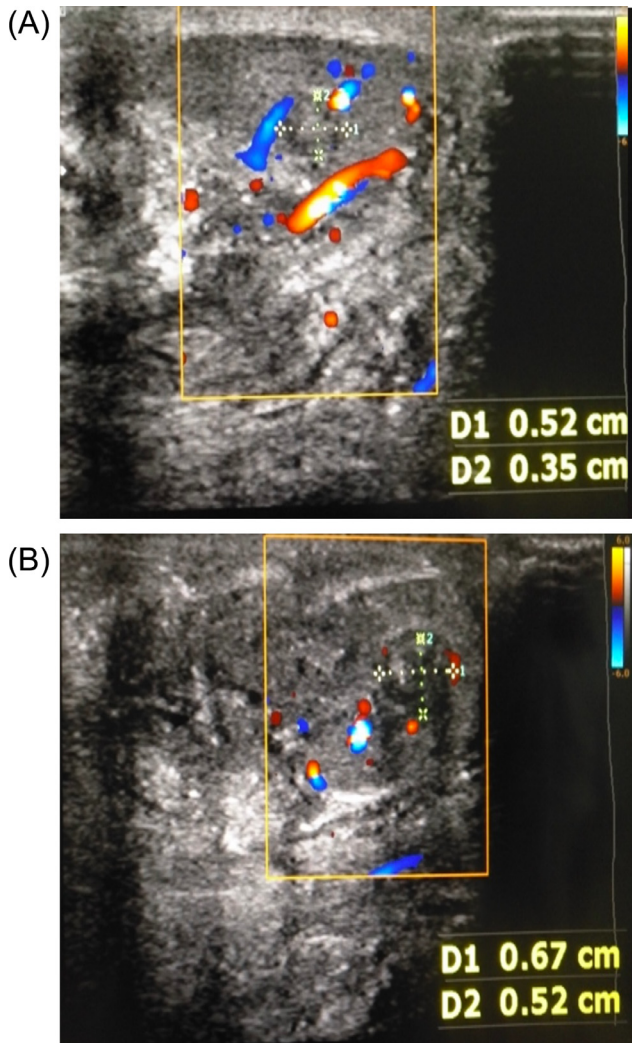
(A) Color Doppler US of scrotum showing iso to heteroechoic nodules within right testis with increased vascularity. (B) Color Doppler US of scrotum showing iso to heteroechoic nodules within left testis with increased vascularity.
